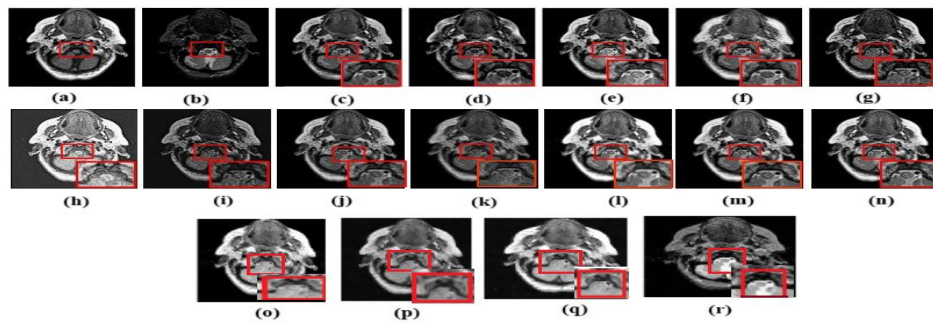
Output image of proposed image fusion model and existing models ((a) source image CT (b) source image MRI (c) GFF (d) RPCNN (e) LPCNN (f) NSST+PAPCNN (g) IFCNN (h) PMGI (i) U2 fusion (j) EWC (k) Adapter (l) EWC + Adapter (m) OWMI (n) TDAN (o) proposed model (PCA [13]) with activation function-1 (p) proposed model (PCA [13]) with activation function-2 (q) proposed model (mean-max [85]) with activation function-1 (r) proposed model (mean-max [85]) with activation function-2)
